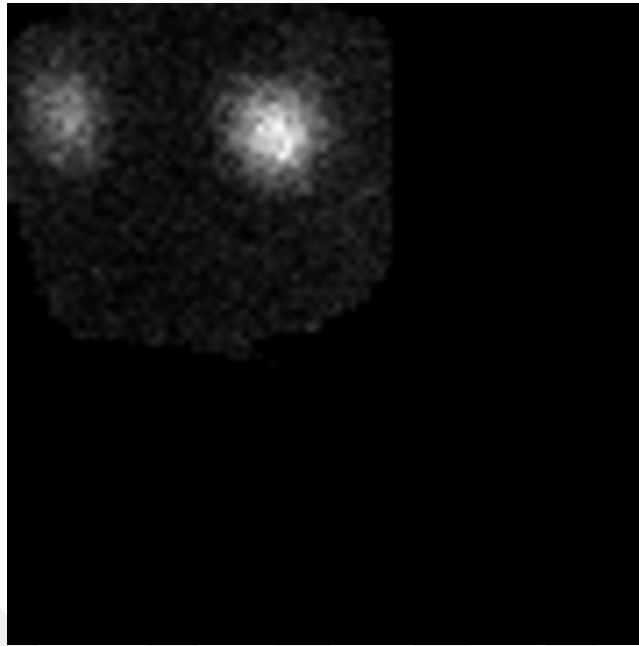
Demonstration of scintigraphic hyperactive nodule image
